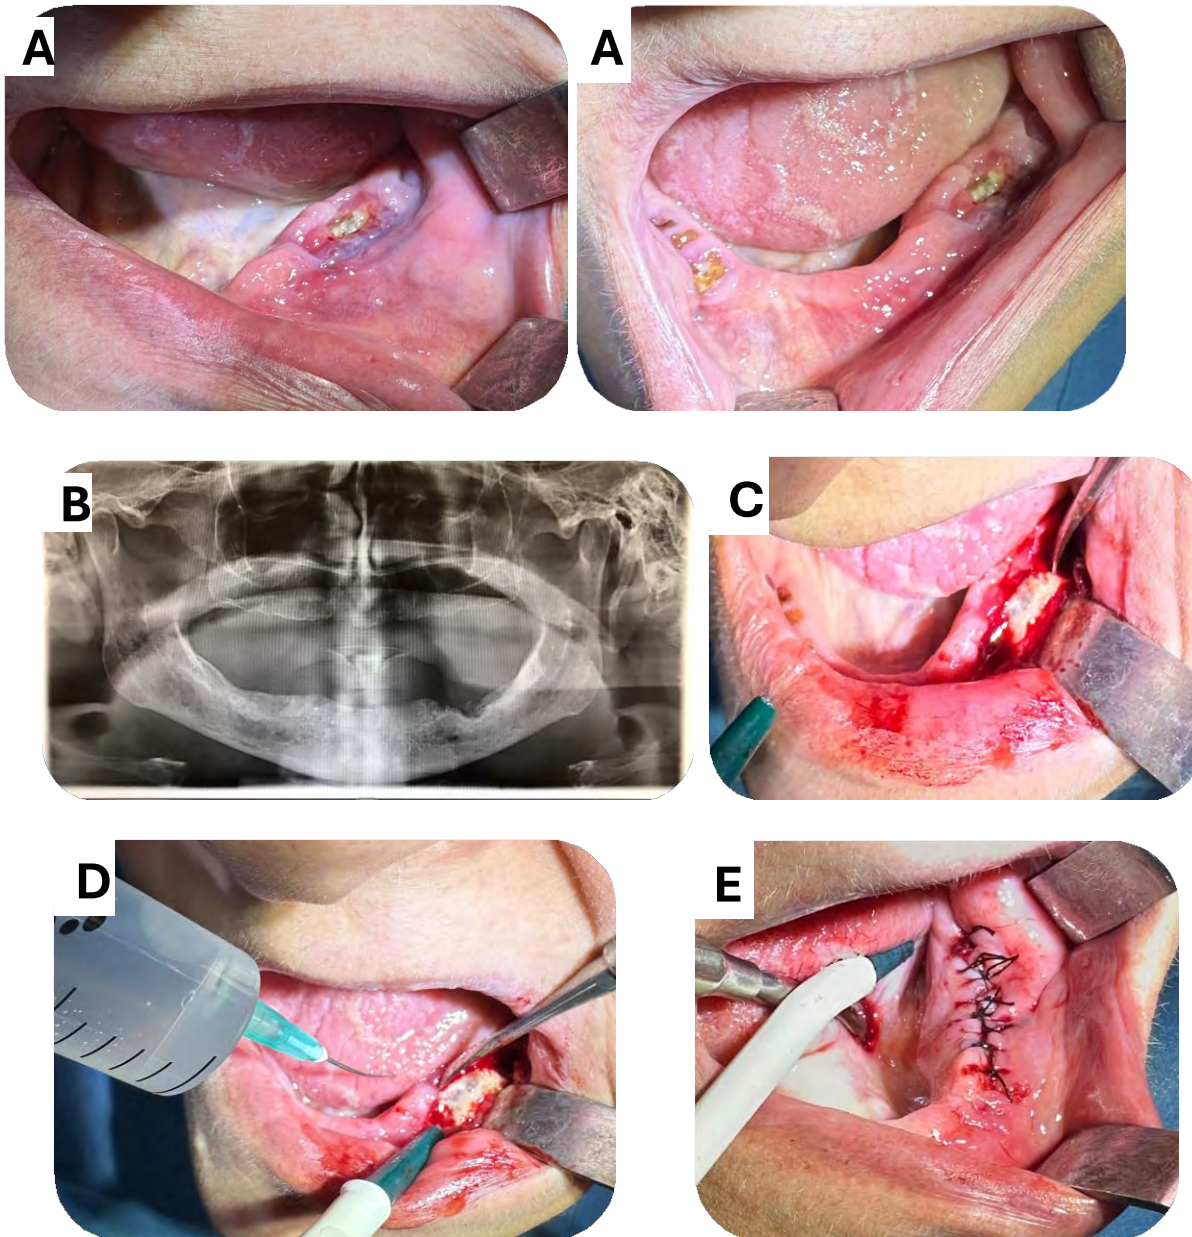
A: Preoperative intraoral view , B: Preoperative radiographic view , C: Exposed necrotic bone view , D: Intraoperative debridement of necrotic bone, E: Postoperative view
